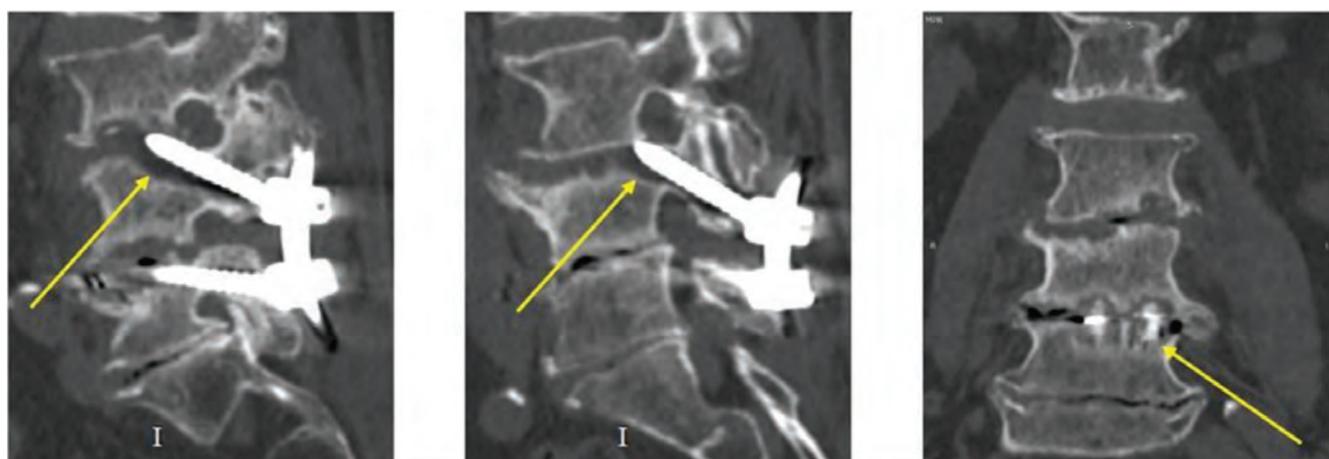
3 months after surgery, X-ray control reveals instrumentation failure with cage subsidence and dislocation of the upper CBT pedicle screws.
